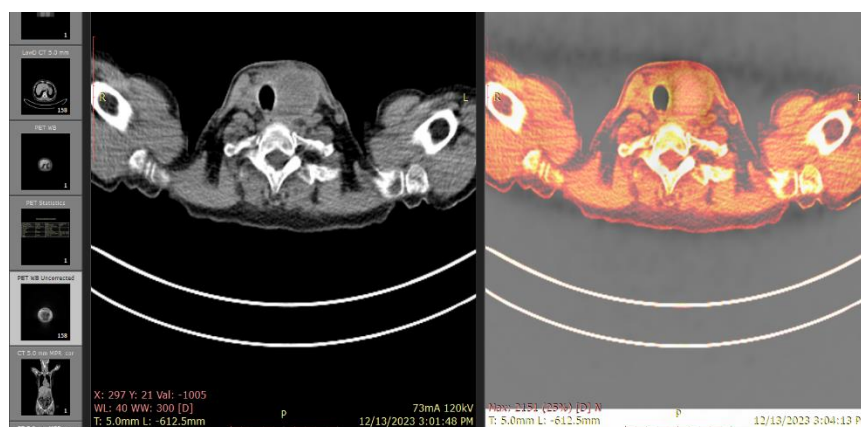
PET CT on 13 December 2023.
